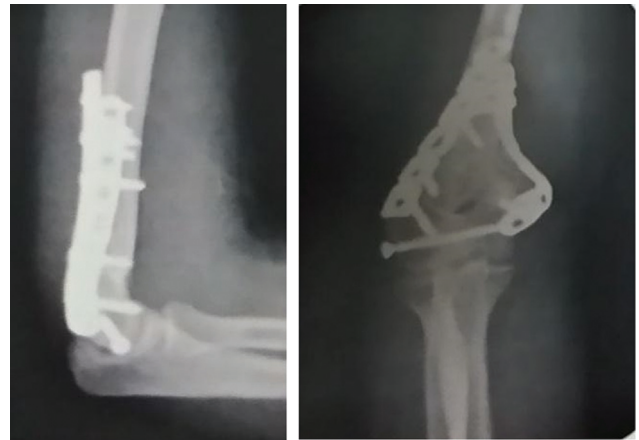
Case 2: triceps-reflecting approach; X-ray at the last follow-up.
